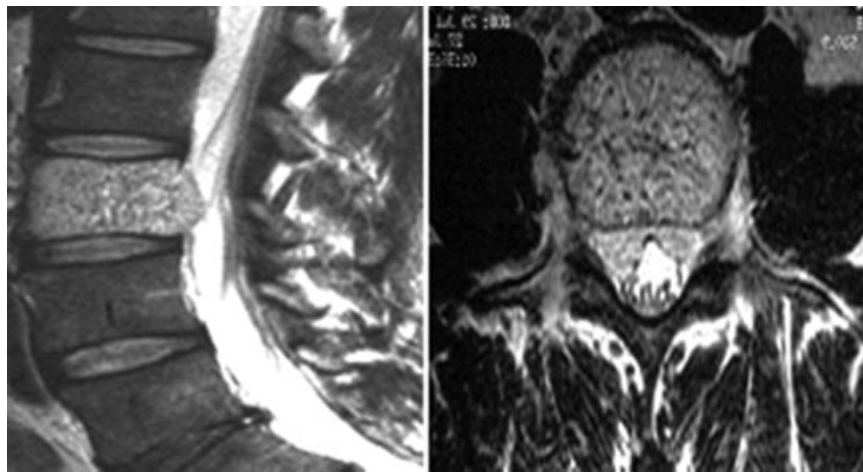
Magnetic resonance image of L3 vertebral body hemangioma with epidural extension.
